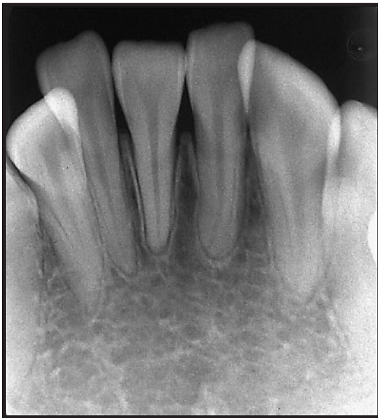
Dental radiograph
